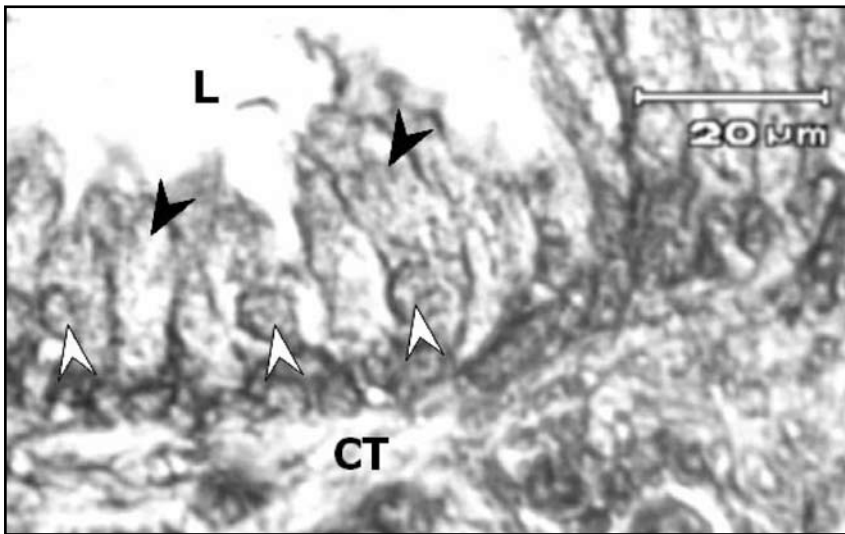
Photograph of normal human prostate gland after treatment with anti-ubiquitin. Portion of prostatic acinus is shown. Very mild immunoreactivity is shown in the nuclei of lining epithelium (white arrow heads) while the cytoplasm shows mild reaction for ubiquitin (black arrow heads). The lumen of the acinus (L) shows no reaction. Fibromuscular compartment of the connective tissue (CT) also shows a positive reaction for ubiquitin.
